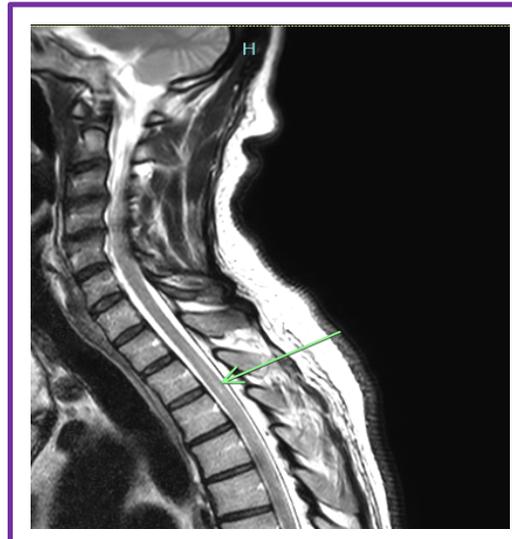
MRI of the thoracic spinal cord with area of demyelination.
